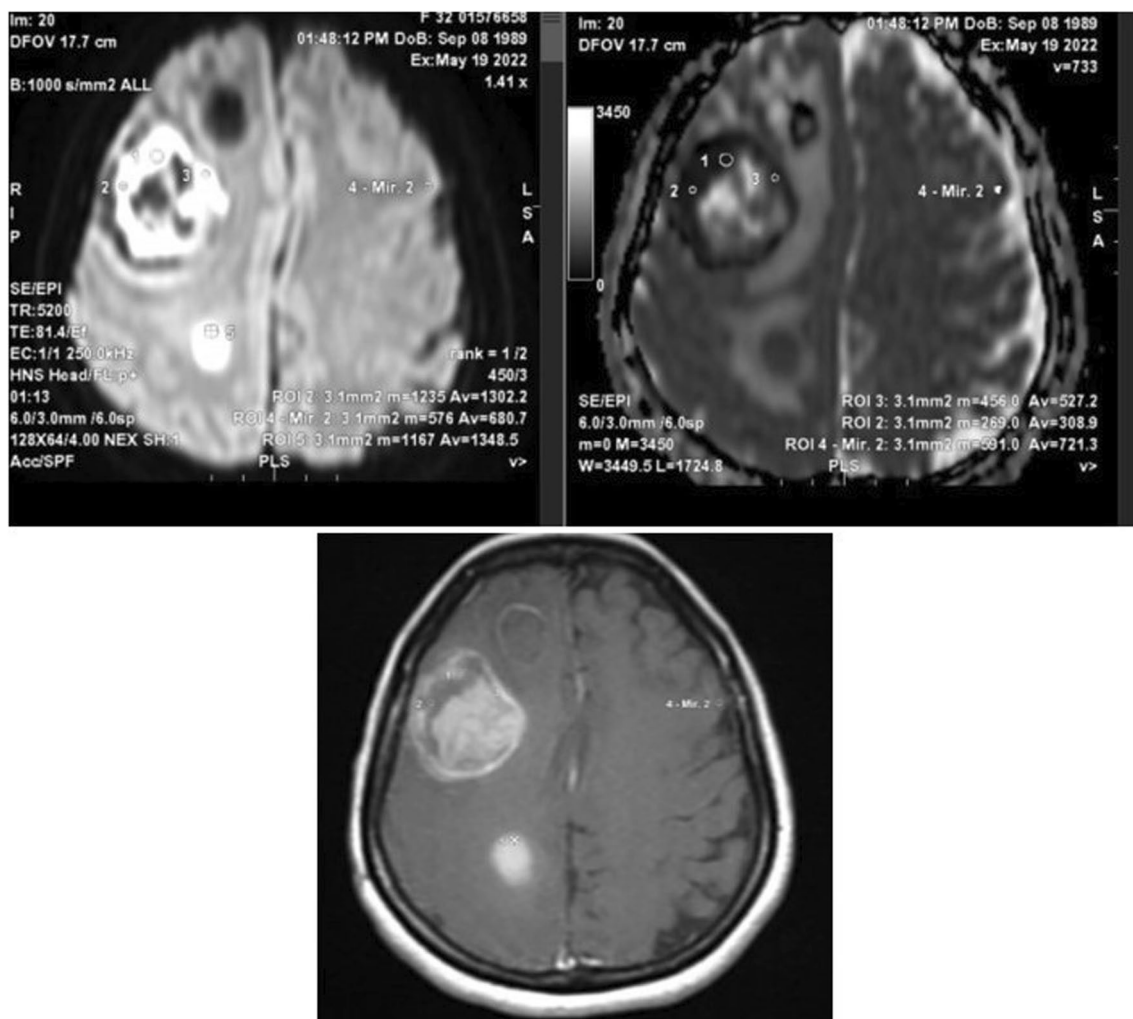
The biggest lesion from multiple brain metastasis lesions was chosen for placing ROI and measuring the ADC value. Hyperintensity in DWI sequence was confirmed by ADC hypo intensity; T1 with contrast confirmed that the lesions had absorbed contrast media heterogeneously to ease the identification of lesion edge (Author's courtesy)
